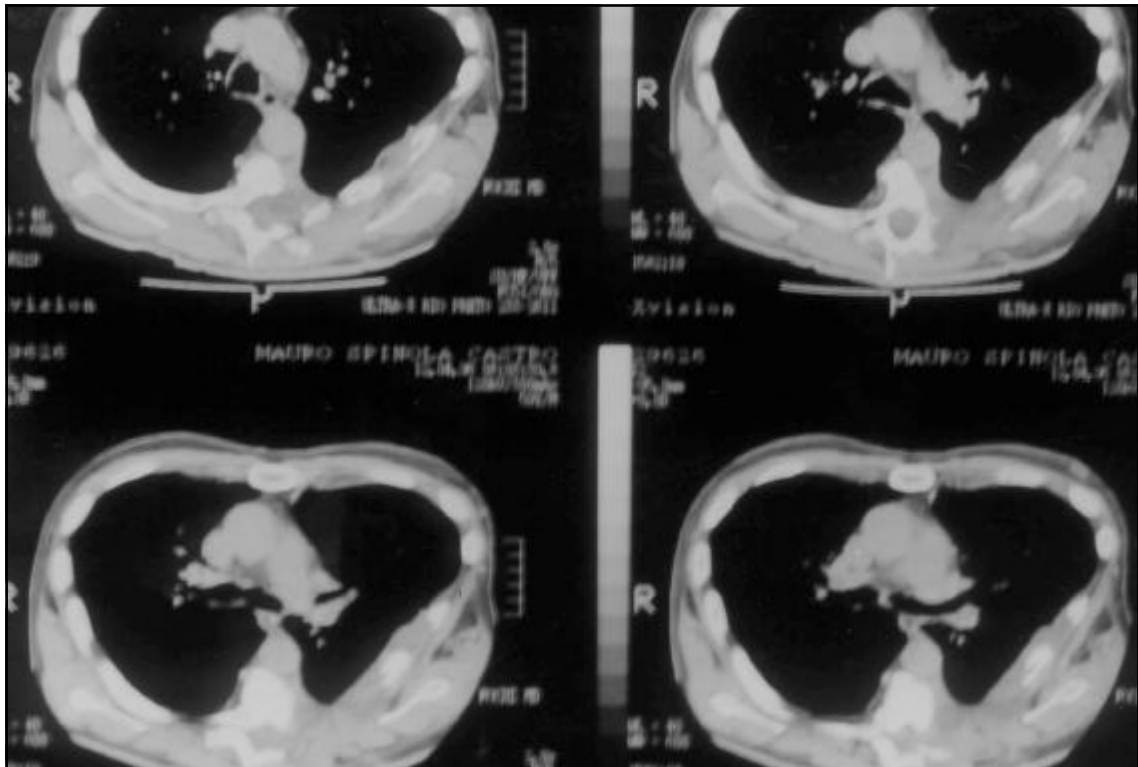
A post-operative transversal thorax CT scan with a follow-up in 10 years without tumors lesions.
